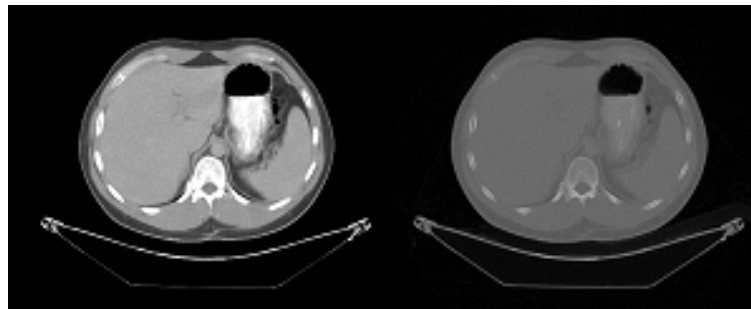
CT image with (left) and without (right) intensity windowing.
